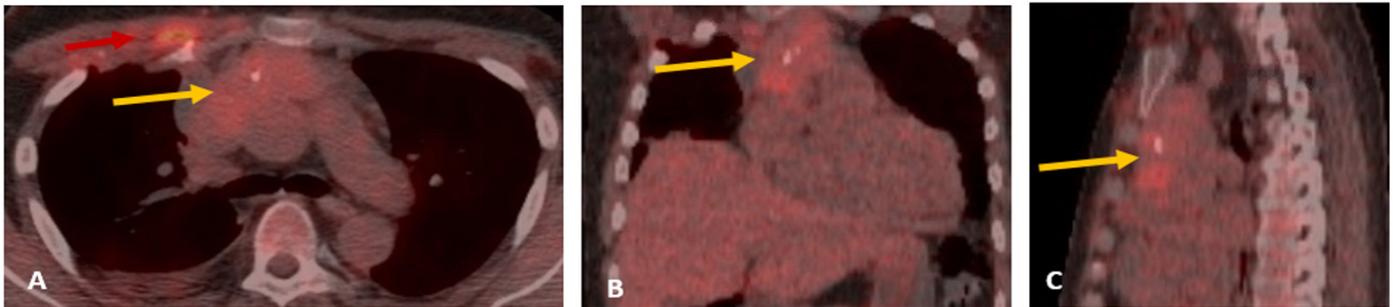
Positron emission computed tomography-CT fusion. (A) axial, (B) coronal and (C) sagittal images show moderate increase of FDG avidity within the anterior mediastinal soft tissue mass (yellow arrows). Red arrow within the axial view represents postsurgical changes.
